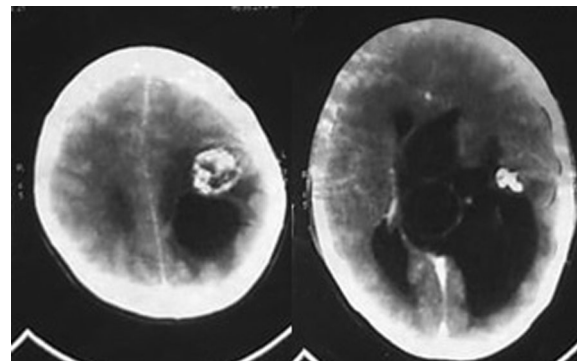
Contrast-enhanced CT scan imaging showing heterogeneous cystic lesion with calcifications and multiple cystic lesions
